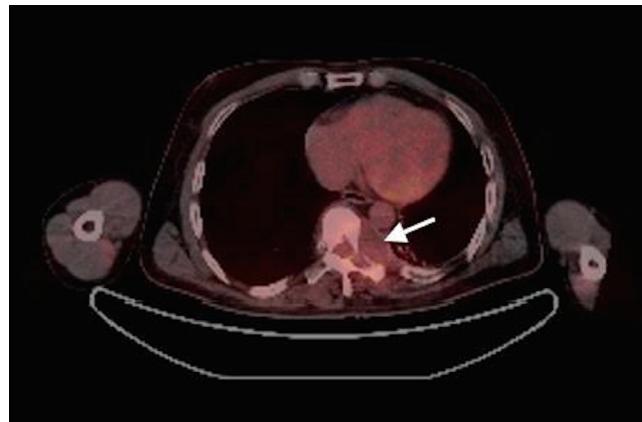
PET-CT images show the destructive mass lesion at the left vertebral transverse process and corpus vertebrae with a calculated SUV max value of 6.17.
